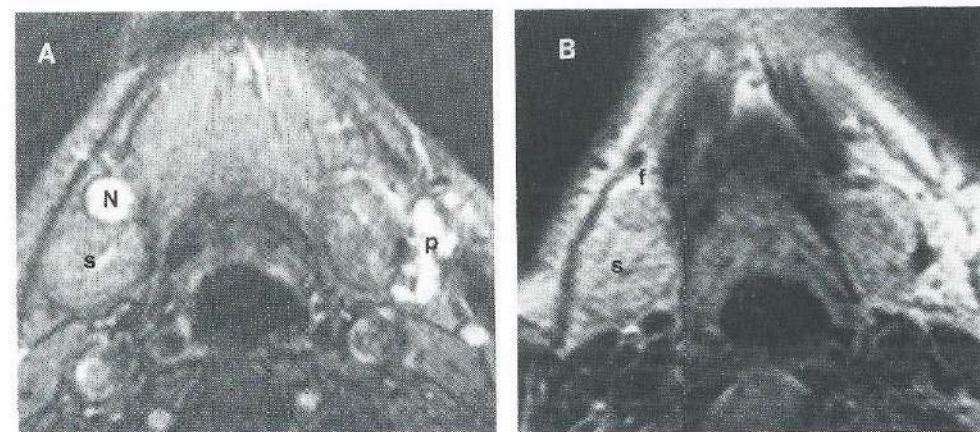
A. T2-weighted GE image of case 10: T2N1 floor of mouth carcinoma. A metastatic submandibular node (N) on the right side is depicted with high signal intensity, in high contrast to all surrounding tissues. The signal of the node is not fully homogenous. The high signal intensity lesion on the left side (p), although never proven, could very well be a parotid tumor. s = submandibular gland. B. T2-weighted SE image. Submandibular gland, fat (f) and the nodal metastasis are now depicted with intermediate to high signal intensity and minimal contrast.
